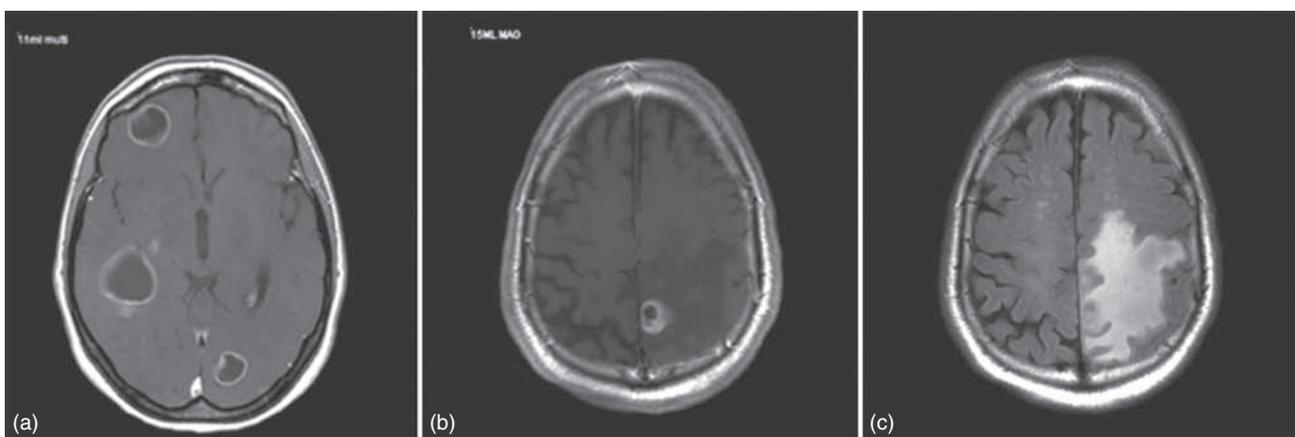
(a) Axial gadolinium-enhanced magnetic resonance (MR) image of multiple cystic ring-enhancing metastases in a patient with small cell lung cancer. (b) Contrasted and (c) FLAIR views of a small convexity metastasis. Even relatively small metastatic tumors are often associated with a tremendous degree of cerebral edema, a hallmark of these lesions.
